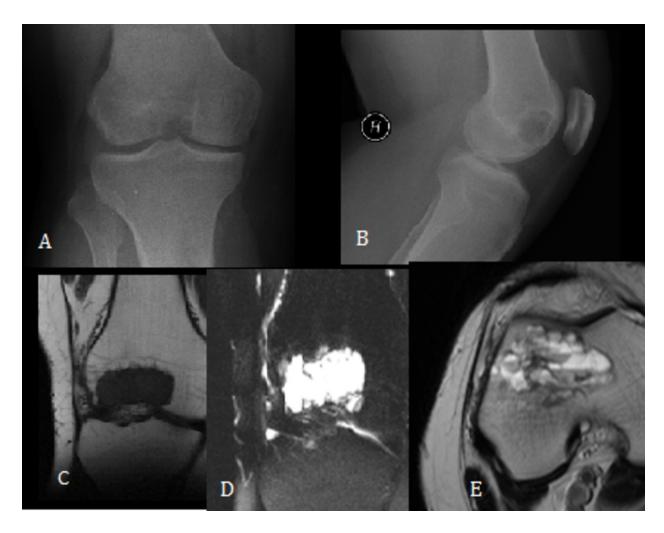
Aneurysmal bone cyst. Frontal (A) and lateral (B) radiographs reveal a well-defined lytic lesion with sclerotic rim located in the central epiphysis with lateral extension. Coronal T1 weighted image (C), coronal fat suppression T2-weighted image (D) and axial T2 without fat supression weighted image (E) reveal a well-defined oval lesion in the epiphysis of the right femur. The lesion has a multiloculated appearance with fluid-fluid levels on T2-weighted images. It appears hypointense on T1 weighted images. No solid component, bone oedema or soft tissue mass associated *References:* Serviço de Imagem Médica, Centro Hospitalar e Universitário de Coimbra, Faculdade de Medicina de Coimbra Medical Imaging Department and Faculty of Medicine, University Hospital of Coimbra, Portugal MRI
